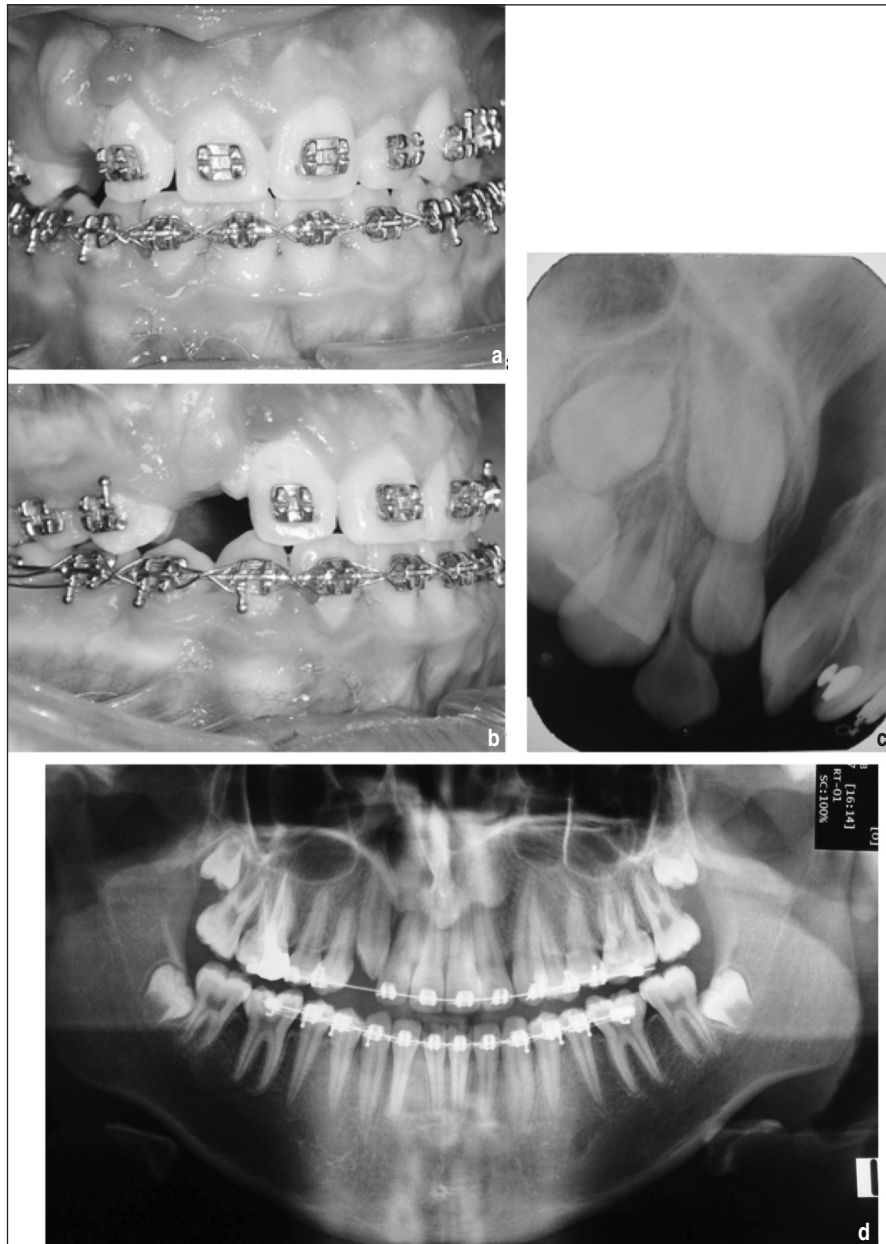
Pre-operative records. a and b. Intraoral photos showing the defect region; c. Periapical radiograph showing alveolar cleft region; d. Panoramic radiograph showing impacted mandibular 3rd molars and cleft region.
